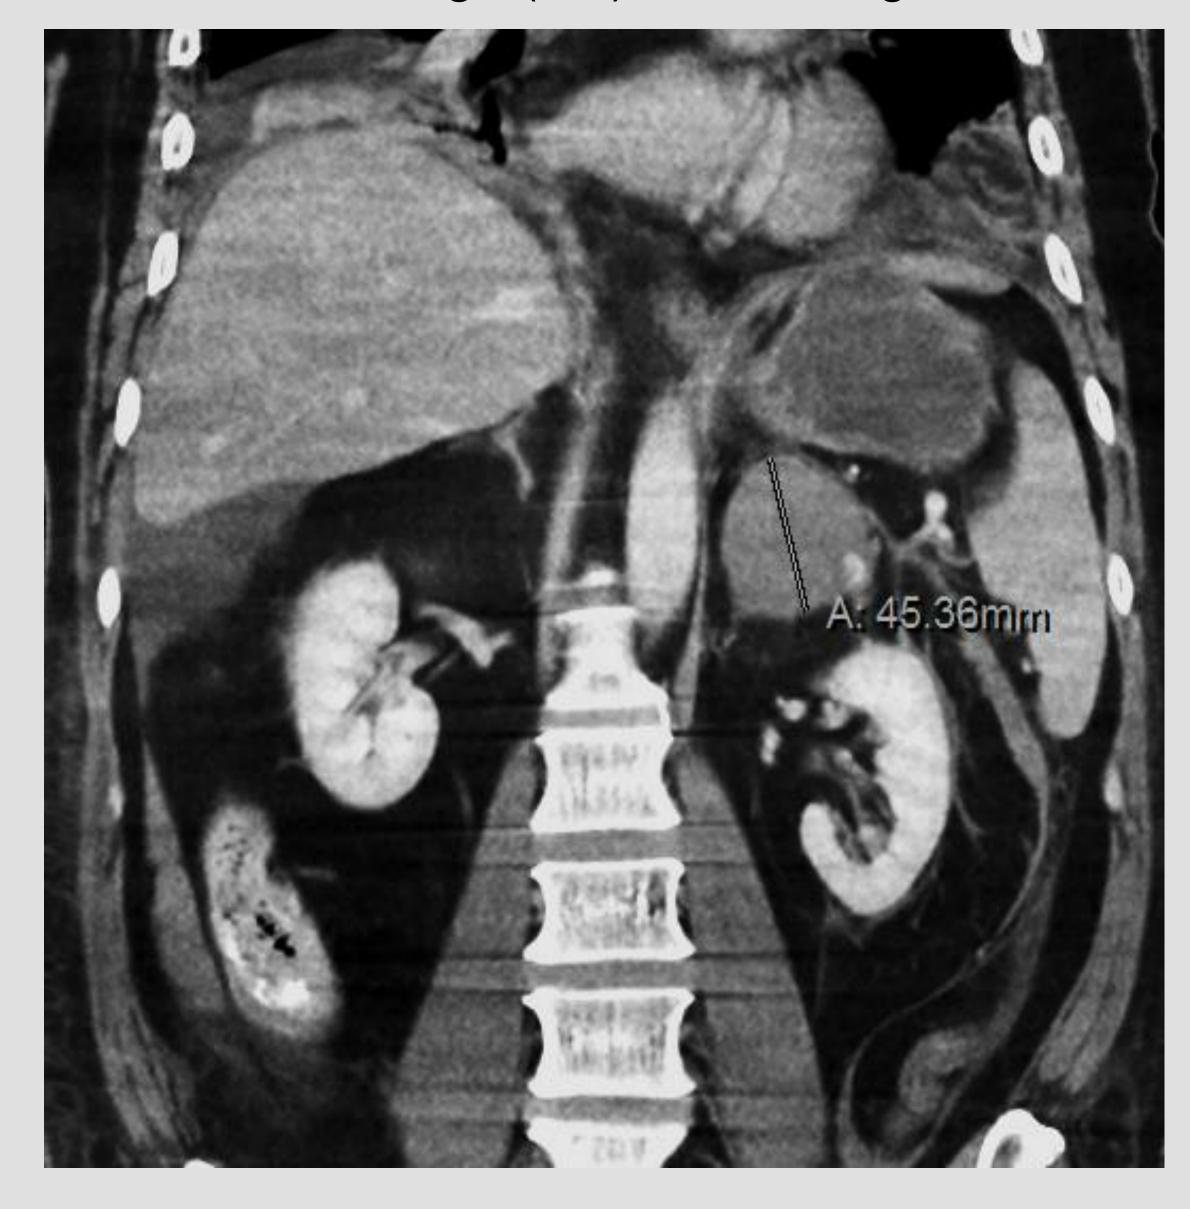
a repeated CTA showed a reduction in clot burden
